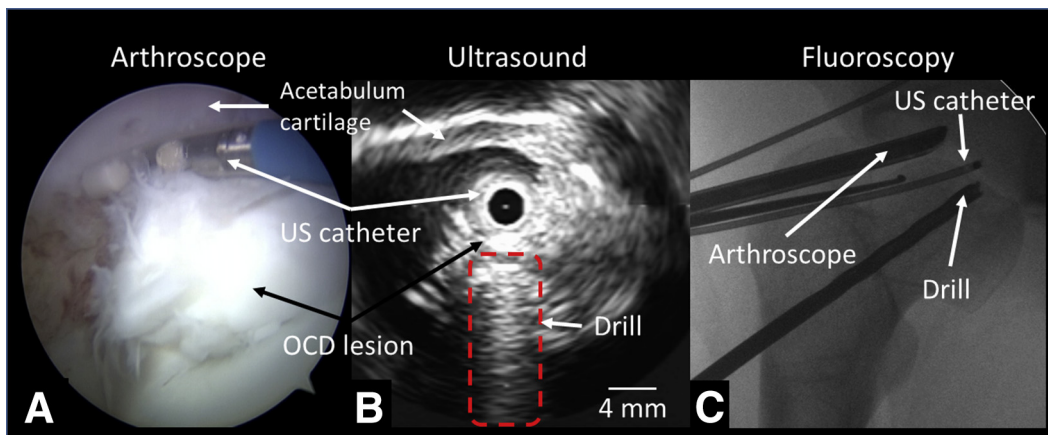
Retrograde drilling of a right hip osteochondritis dissecans (OCD) lesion was possible under arthroscopic ultrasound guidance. (A) Arthroscopic view of OCD lesion from anterolateral portal. (B) Ultrasound image of OCD lesion in coronal plane, showing drill underneath cartilage surface (dashed red box). The ultrasound (US) catheter was inserted into the joint from the anterior portal. (C) Fluoroscopic image of hip (posterior-anterior direction) showing ultrasound (US) catheter, arthroscope, and drill.
